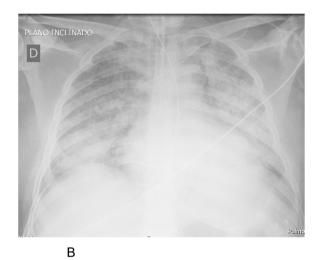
A: X-ray at admission in ICU. B: X-ray 24 h after admission in ICU.
